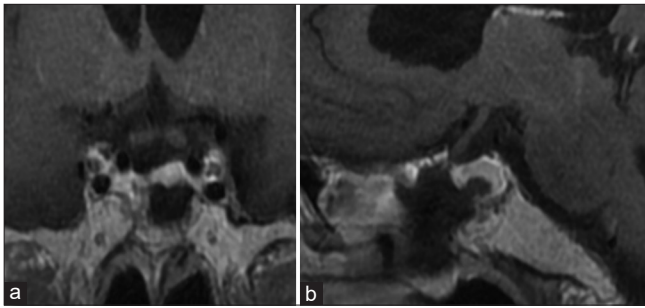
(a) Magnetic resonance imaging (MRI) coronal section MRI after the second operation shows the complete removal of the residual micro pituitary neuroendocrine tumor (PitNET) in the left thin, normal pituitary gland, (b) MRI sagittal section MRI after second operation shows the complete removal of the residual micro PitNET in the left thin, normal pituitary gland.
